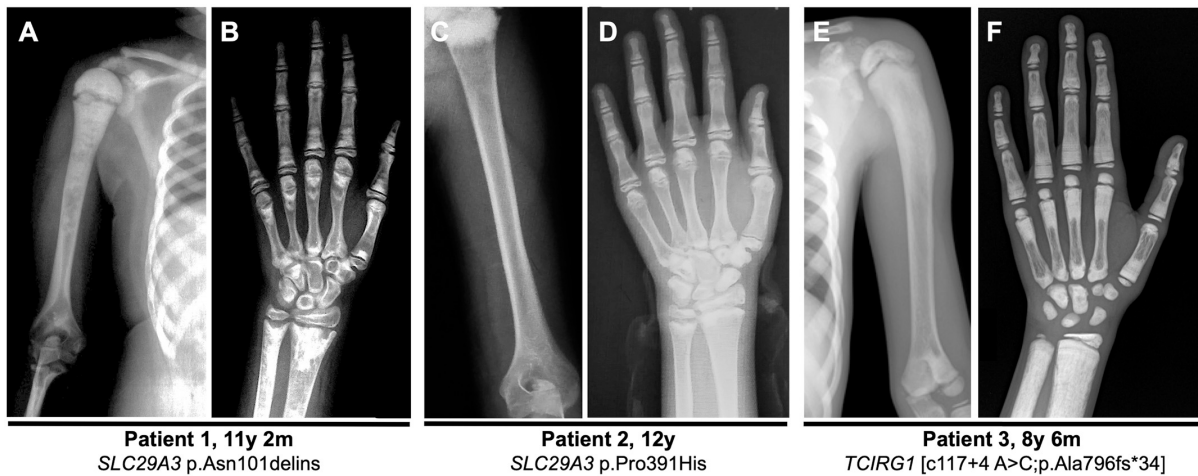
Upper limb radiographs of Patient 1, 2 and 3. (A) Patient 1 presents with sclerotic foci of the humerus in the proximal two thirds and increased corticalis in the distal third of the humerus. The humerus appears slightly broadened and shortened. (B) Radii and ulnae reveal distinct osteosclerosis and a cloudy appearance. Osteosclerotic bands are predominantly present at the growth plates (C) Patient 2 presents with cortical thickening of the humeri and (D) diffuse sclerosis of the digiti, predominantly visible at methaphyseal regions. (E) In Patient 3, the proximal humerus reveals sclerosis and an abnormal curvature. (F) Strong sclerotic bands are present at distal radius and ulna, at the distal end of the metacarpals and the proximal ends of the phalanges.
